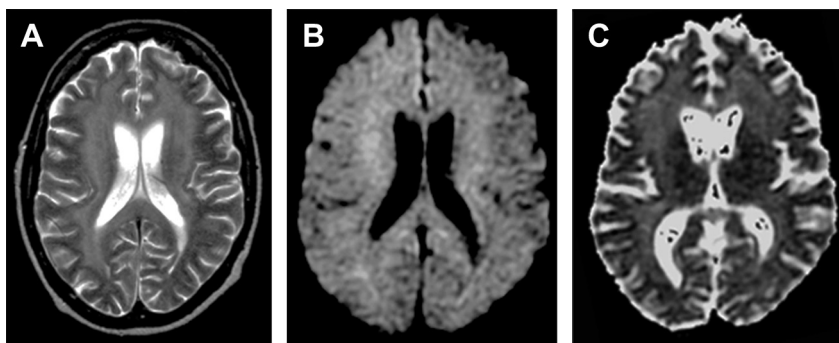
HIV encephalopathy. A 46-year-old man with AIDS dementia complex. T2-weighted image (A) shows diffuse periventricular hyperintense lesions. U fibers are spared. DWI reveals these lesions as mild hyperintensity (B). Apparent diffusion coefficient (ADC) map shows these lesions as increased ADC (C). Mild hyperintensity on DWI is caused by a T2 shine-through effect.
